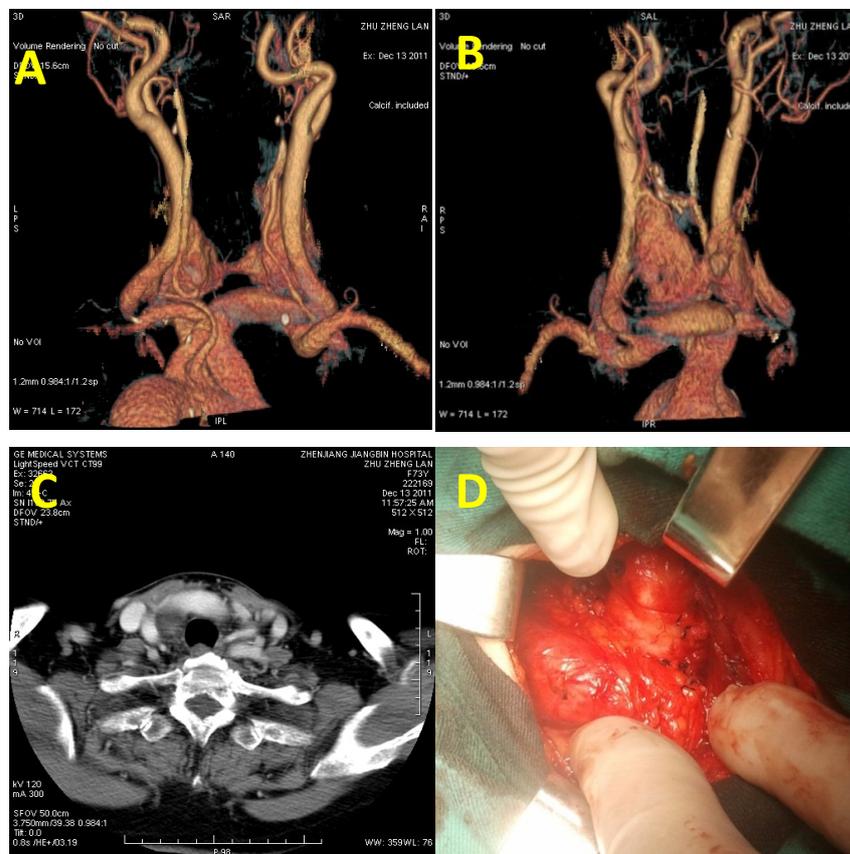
A woman 73-year-old. Patient 18 years ago on physical examination revealed bilateral neck mass, peanut size in the neck A: Axial image at as indications the right brachiocephalic artery overpass anterior to the right lobe of the thyroid gland and lightly superior level. B: Axial image at a additional cranial level displays that the right common artery is posterior to the thyroid gland. C: Axial image right brachiocephalic artery just anterior to the trachea was shows with the help of CT scan at the level of the first thoracic vertebral body. The right subclavian artery proximal portion also seen at this level. D: In the front of thyroid we were find pulsating brachiocephalic artery is about 1.0 cm.
